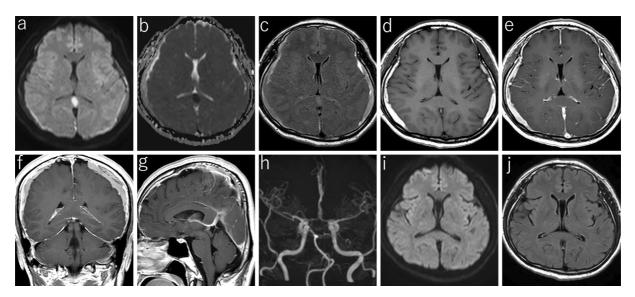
On admission, axial diffusion-weighted image (DWI) (a) and apparent diffusion coefficient (ADC) map (b) demonstrated restricted diffusion in the splenium of the corpus callosum (SCC). Fluid-attenuated invasion recovery (FLAIR) image (c) showed hyperintensity in the SCC. T1-weighted image (T1WI) (d) revealed isointensity in the SCC. The SCC was not enhanced in gadolinium-enhanced (Gd-enhanced) T1WI (e). Coronal Gd-enhanced T1WI presented pachymeningeal enhancement (f). The straight sinus of our patient was standing steeply and the tentorial angle was elevated on sagittal T1-weighted images (g). MR angiography performed to rule out the possibility of a cerebral aneurysm was unremarkable (h). Following a lumbar epidural blood patch, the splenial lesion disappeared in DWI (i) and ADC map (j) on day 100.
